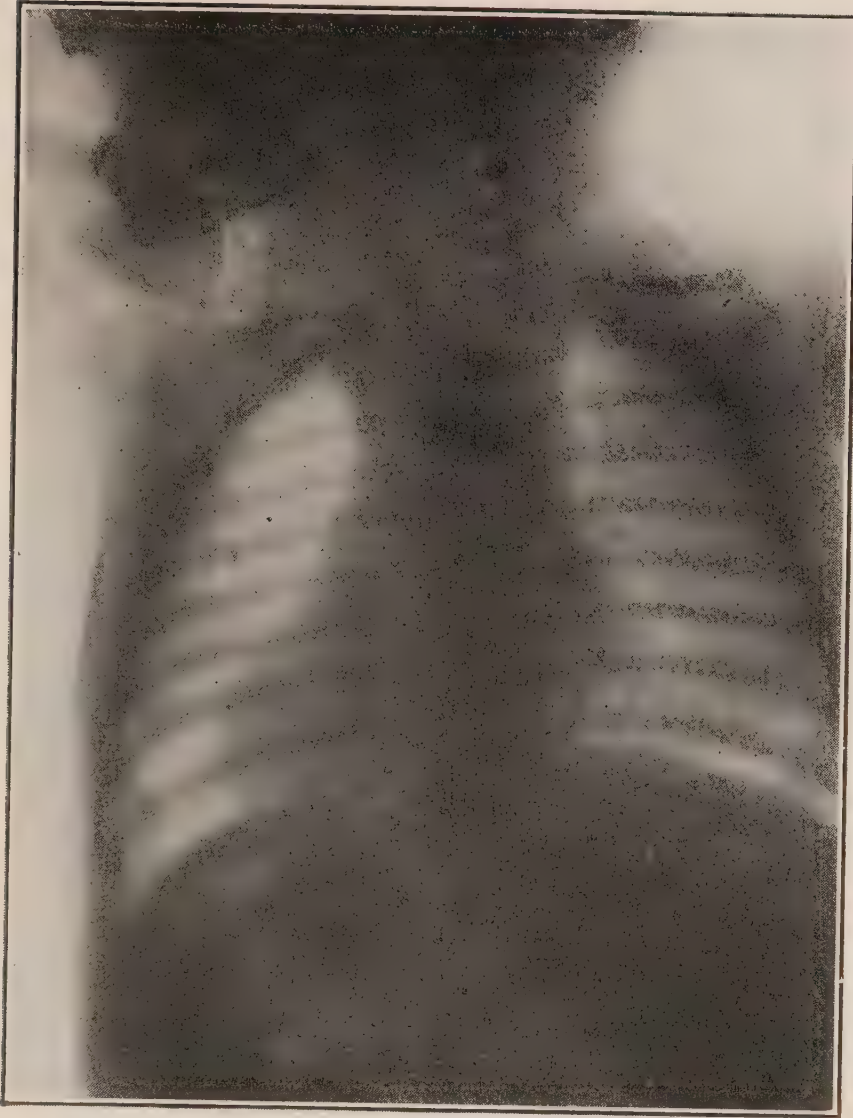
Radiograph of cuff-link in the œsophagus of a child 17 months old. Cuff-link removed by œsophagoscopy, bloodlessly, through the mouth, without anæsthesia, general or local. (*Author's case. Radiograph by Johnston and Grier.*)
